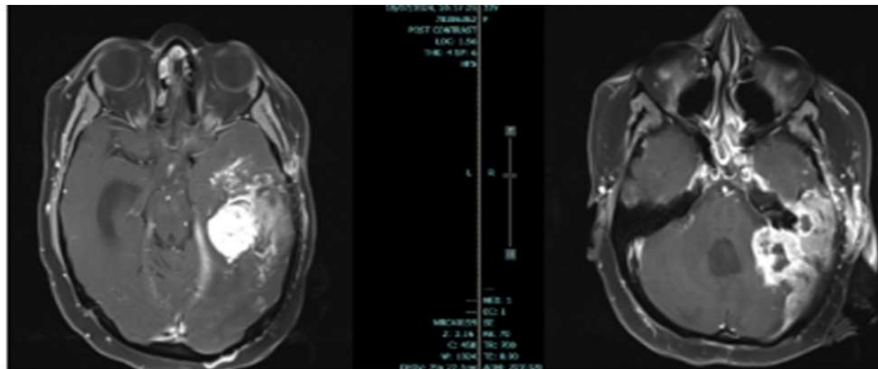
After 6 month MRI showing recurrent lesion.
